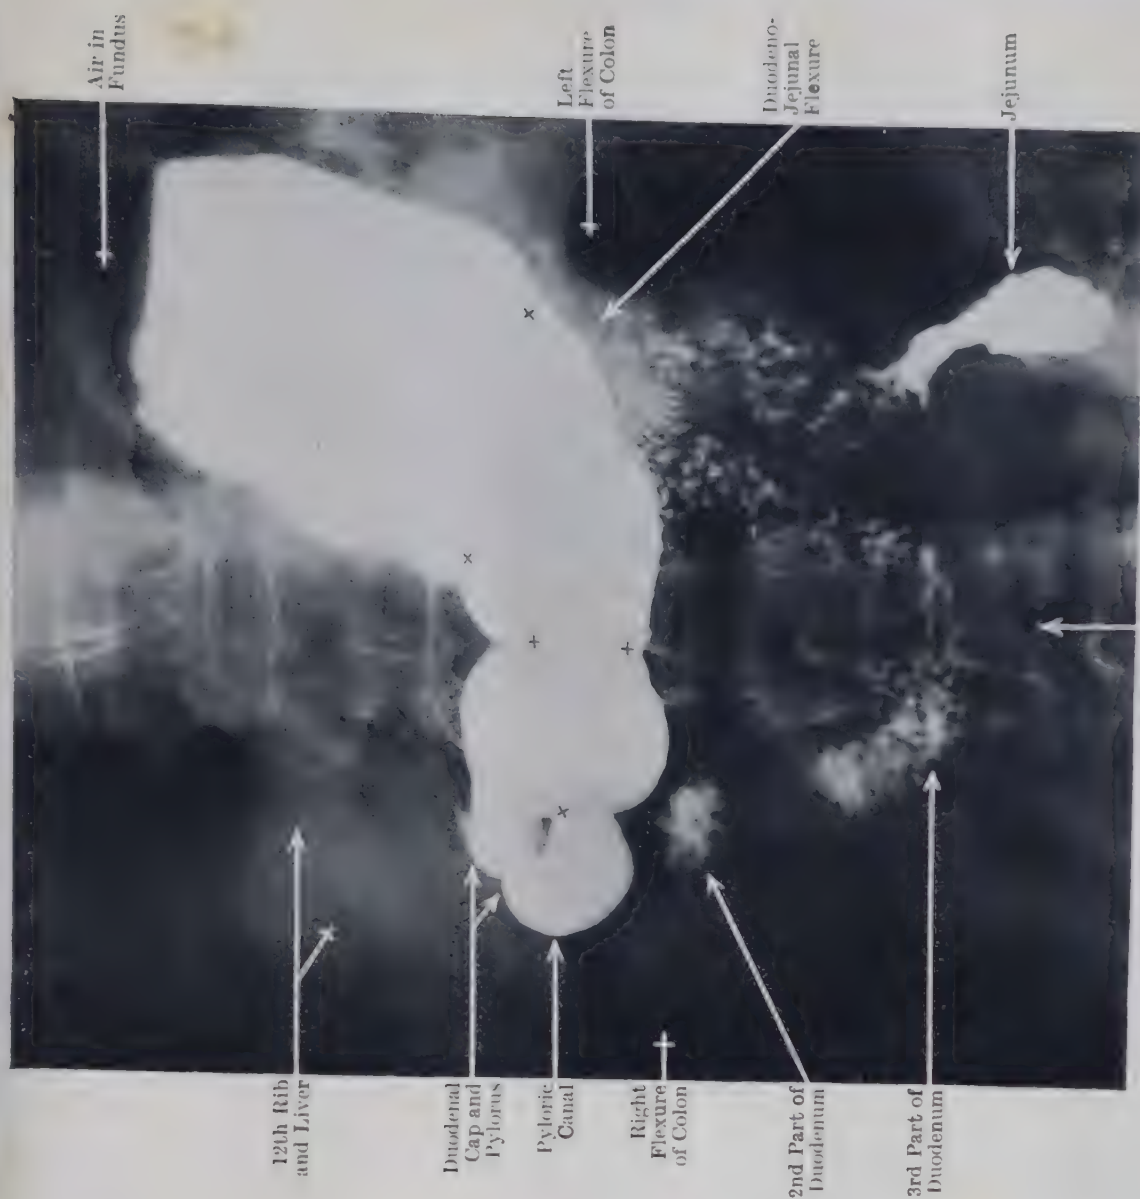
RADIOGRAPH OF "STEER-HORN" STOMACH (MAN, AGED 51), FILLED WITH BARIUM, SHOWING A SERIES OF PERISTALTIC WAVES (x). Note the mucosal folds in the Duodenum and Jejunum and the outlining of the Large Intestine by gas.
